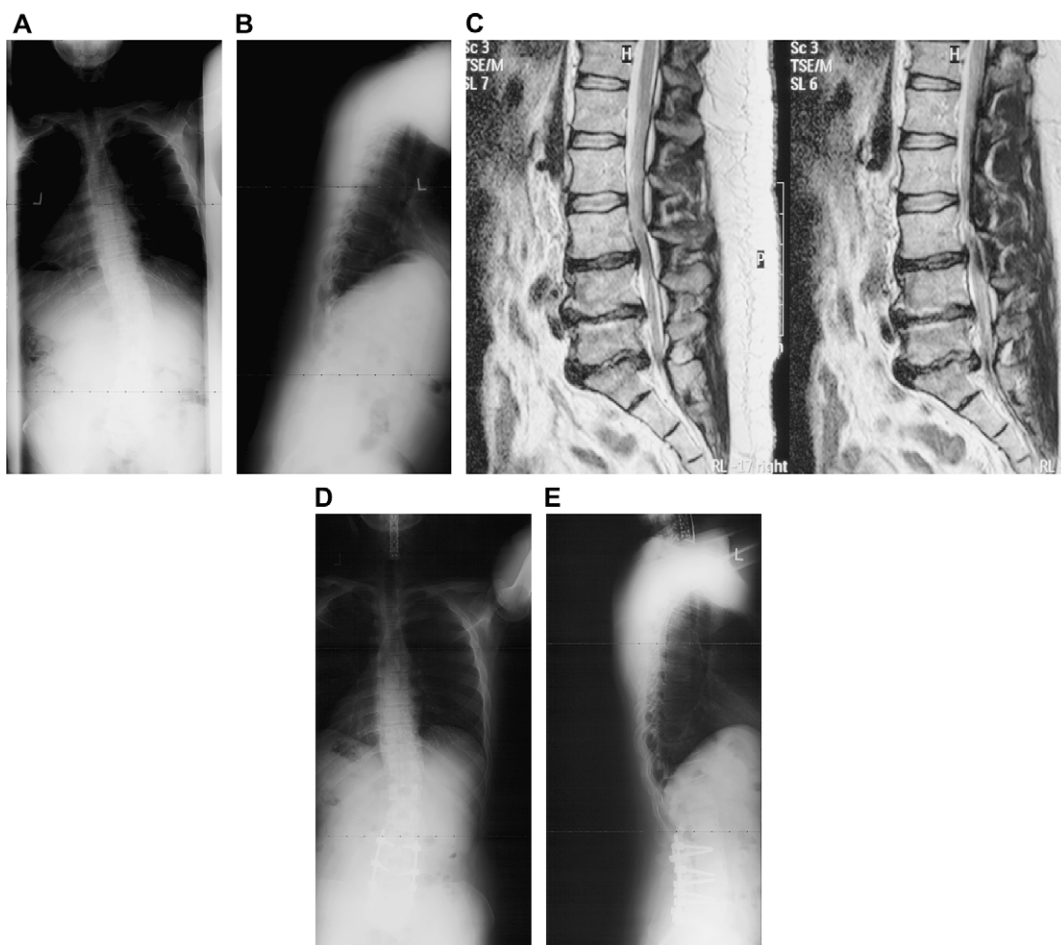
Standing 36" posteroanterior (A) and lateral (B) radiographs demonstrate significant loss of lumbar lordosis and positive sagittal balance in a patient with severe degenerative disease of the lumbar spine (C). (D, E) Surgical treatment included anterior releases and lordotic interbody grafts as well as posterior osteotomies and correction with instrumentation.
